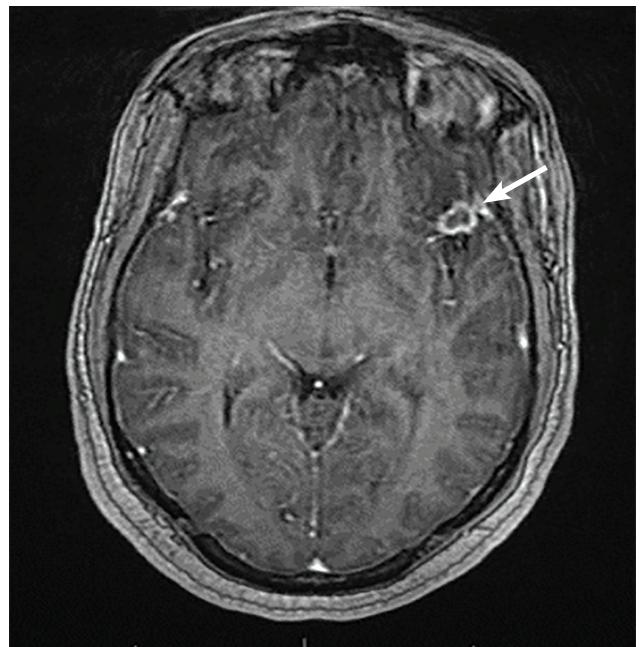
Tumor or abscess? T1-weighted magnetic resonance imaging with contrast, obtained soon after presentation, showed a 1.2-cm ring-enhancing lesion (arrow). Diffusion-weighted imaging did not show restricted diffusion.
